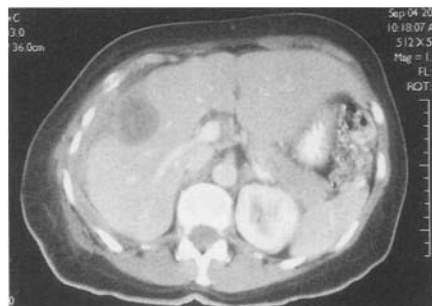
CT scan: 66 year old lady with proven mesothelioma. There is an extensive tumour within the right hemithorax (not shown) which has directly invaded the liver having penetrated the diaphragm
